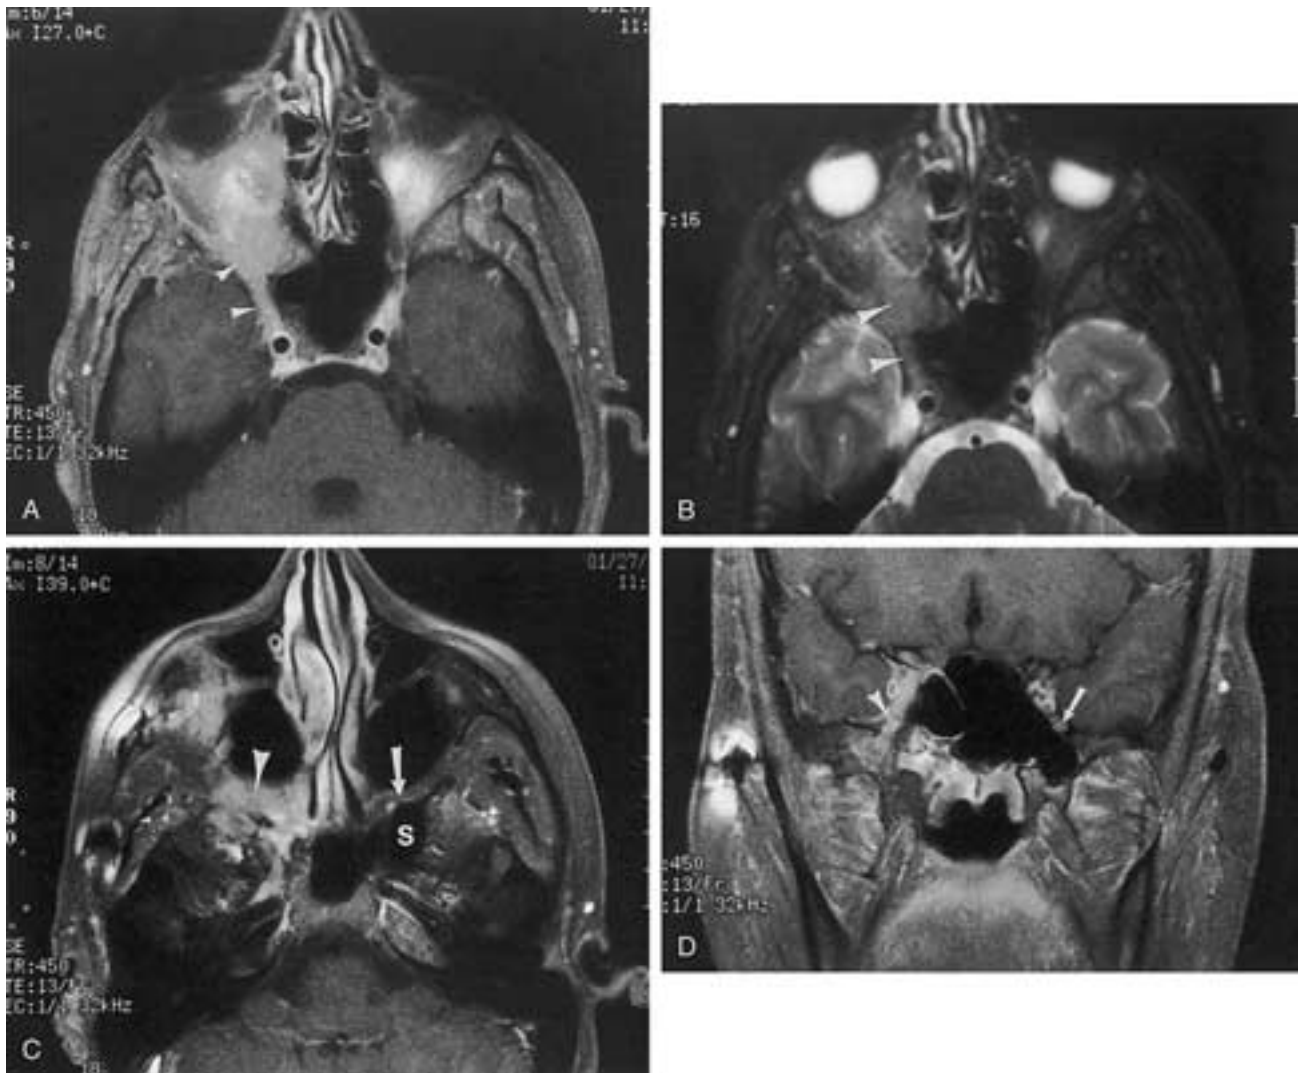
Diffuse neurofibroma extending along branches of the trigeminal nerve. A, Axial T1-weighted postcontrast image with fat suppression shows the tumor (*white arrowheads*) extending from the cavernous sinus anteriorly into the orbital apex and upper pterygopalatine fossa. B, T2-weighted image again shows the tumor (*arrowheads*), which has a fairly low signal intensity. C, Scan inferior to A shows the tumor (*white arrowhead*) filling and expanding the pterygopalatine fossa. Compare this with the normal pterygopalatine fossa (*arrow*) on the opposite side. In this fat-suppressed image, the signal within the normal pterygopalatine fossa is low. A laterally extending air cell from the sphenoid sinus (*S*) is seen extending into the attachment of the pterygoid plate. D, The tumor is seen in the anterior cavernous sinus and posterior superior orbital fissure (*open arrow*). The arrowhead indicates the approximate position of the foramen rotundum. The normal foramen rotundum on the opposite side (*arrow*) is identified. Again, note that the expanding sphenoid air cell on the normal side extends between the foramen rotundum and the Vidian canal. (Courtesy of Dr. Norman Leeds.)
